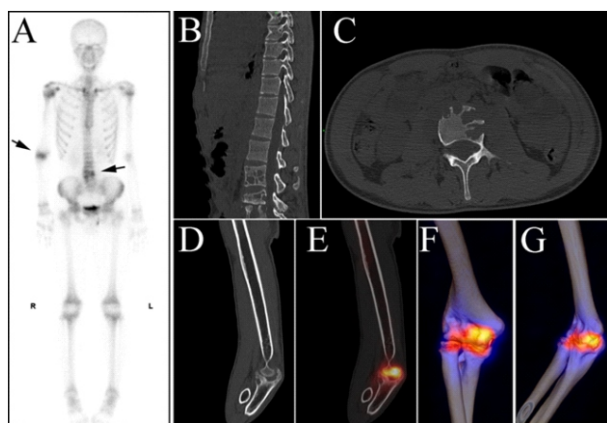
Single photon emission tomography/CT imaging (with ^{99m}Tc -MDP) of patients with osteoarticular TB. A-G, A 17 years old boy with spinal and elbow TB. The anterior maximum intensity projection images (A) showed abnormal activity at the L2-L5 vertebrae and the right elbow joint. (B, C and D) CT images showed bone destruction in these sites. The SPET/CT (E) and 3D-SPET (F and G) images not only showed the metabolic status of the lesions, but also determined the location of the lesions more clearly and intuitively.
